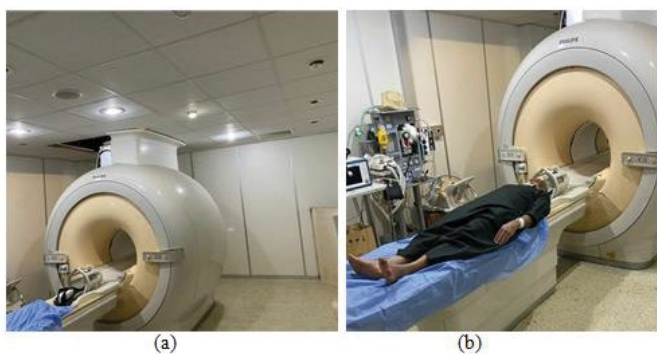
(a) The MRI device that was used in the process of this research. (b) The MRI device that was used in the process of this research during the examination.
